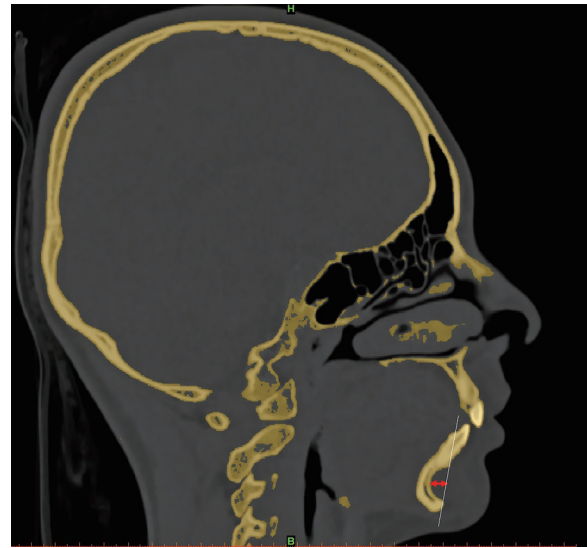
Sagittal view computed tomographic scan of the skull. The red arrow indicates the bone erosion in the mentum.
